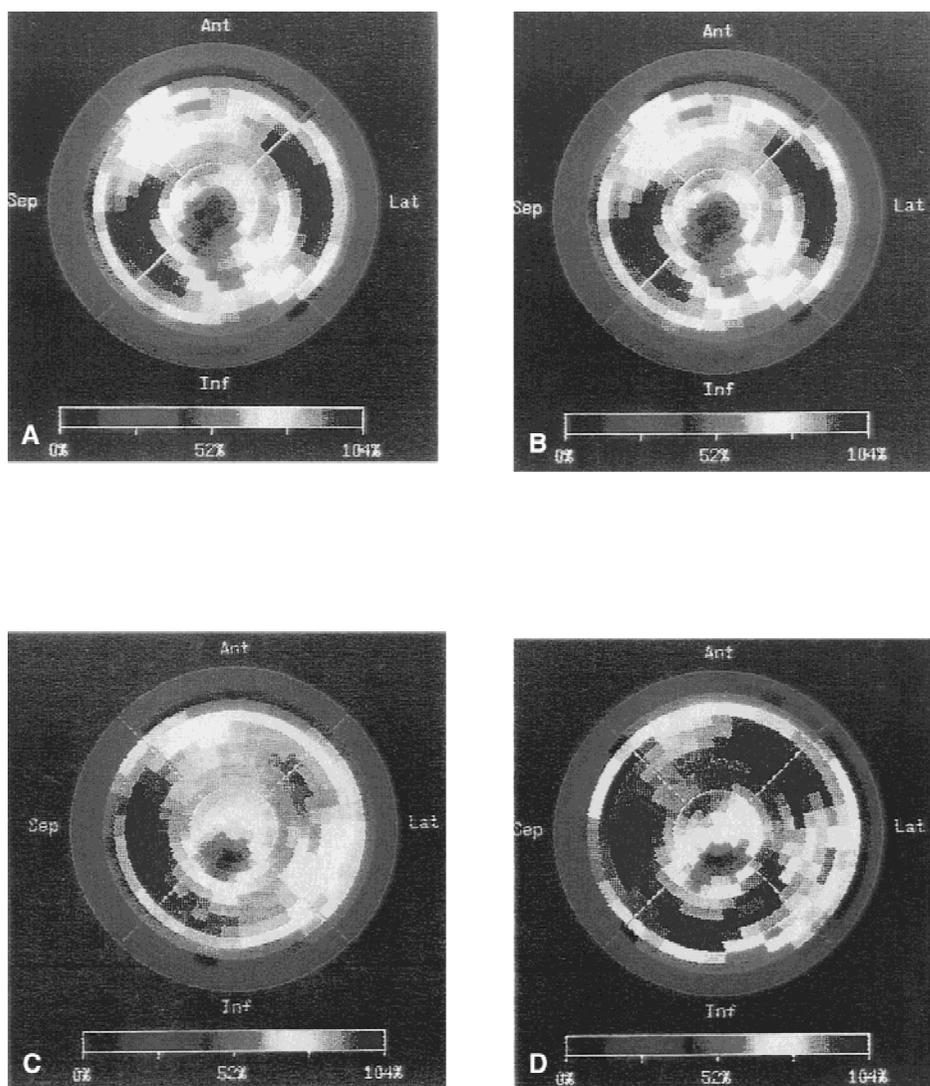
Example of a PET study. Image A show the baseline “stress” study where NH_3 is used to study MPI. Tracer activity is represented by a grey scale where white represents greatest activity, and black being the least. All images are presented as “bullseye equivalent” images with the top part of the image representing the anterior region (ant), the bottom of the image represents the inferior (inf) region of the left ventricle, while the 9 o’clock position represents the septum (sep) and the 3 o’clock position represents the lateral wall of the heart. In the initial PET image, activity is decreased anteriorly, inferiorly, and apically. Image B shows MV as determined by FDG activity. The anterior, apical, and inferior regions supplied by the LAD and RCA demonstrate decreased MV. Image C shows the results of MPI following “stress” 1 year later. There is no difference in myocardial blood flow following “stress” image acquisition over the course of one year of treatment (image C versus image A). However, MV imaging after one year of treatment (image D) demonstrated considerable improvement in all regions when compared with image B, except for the apex where prior myocardial infarction was seen in both studies.
